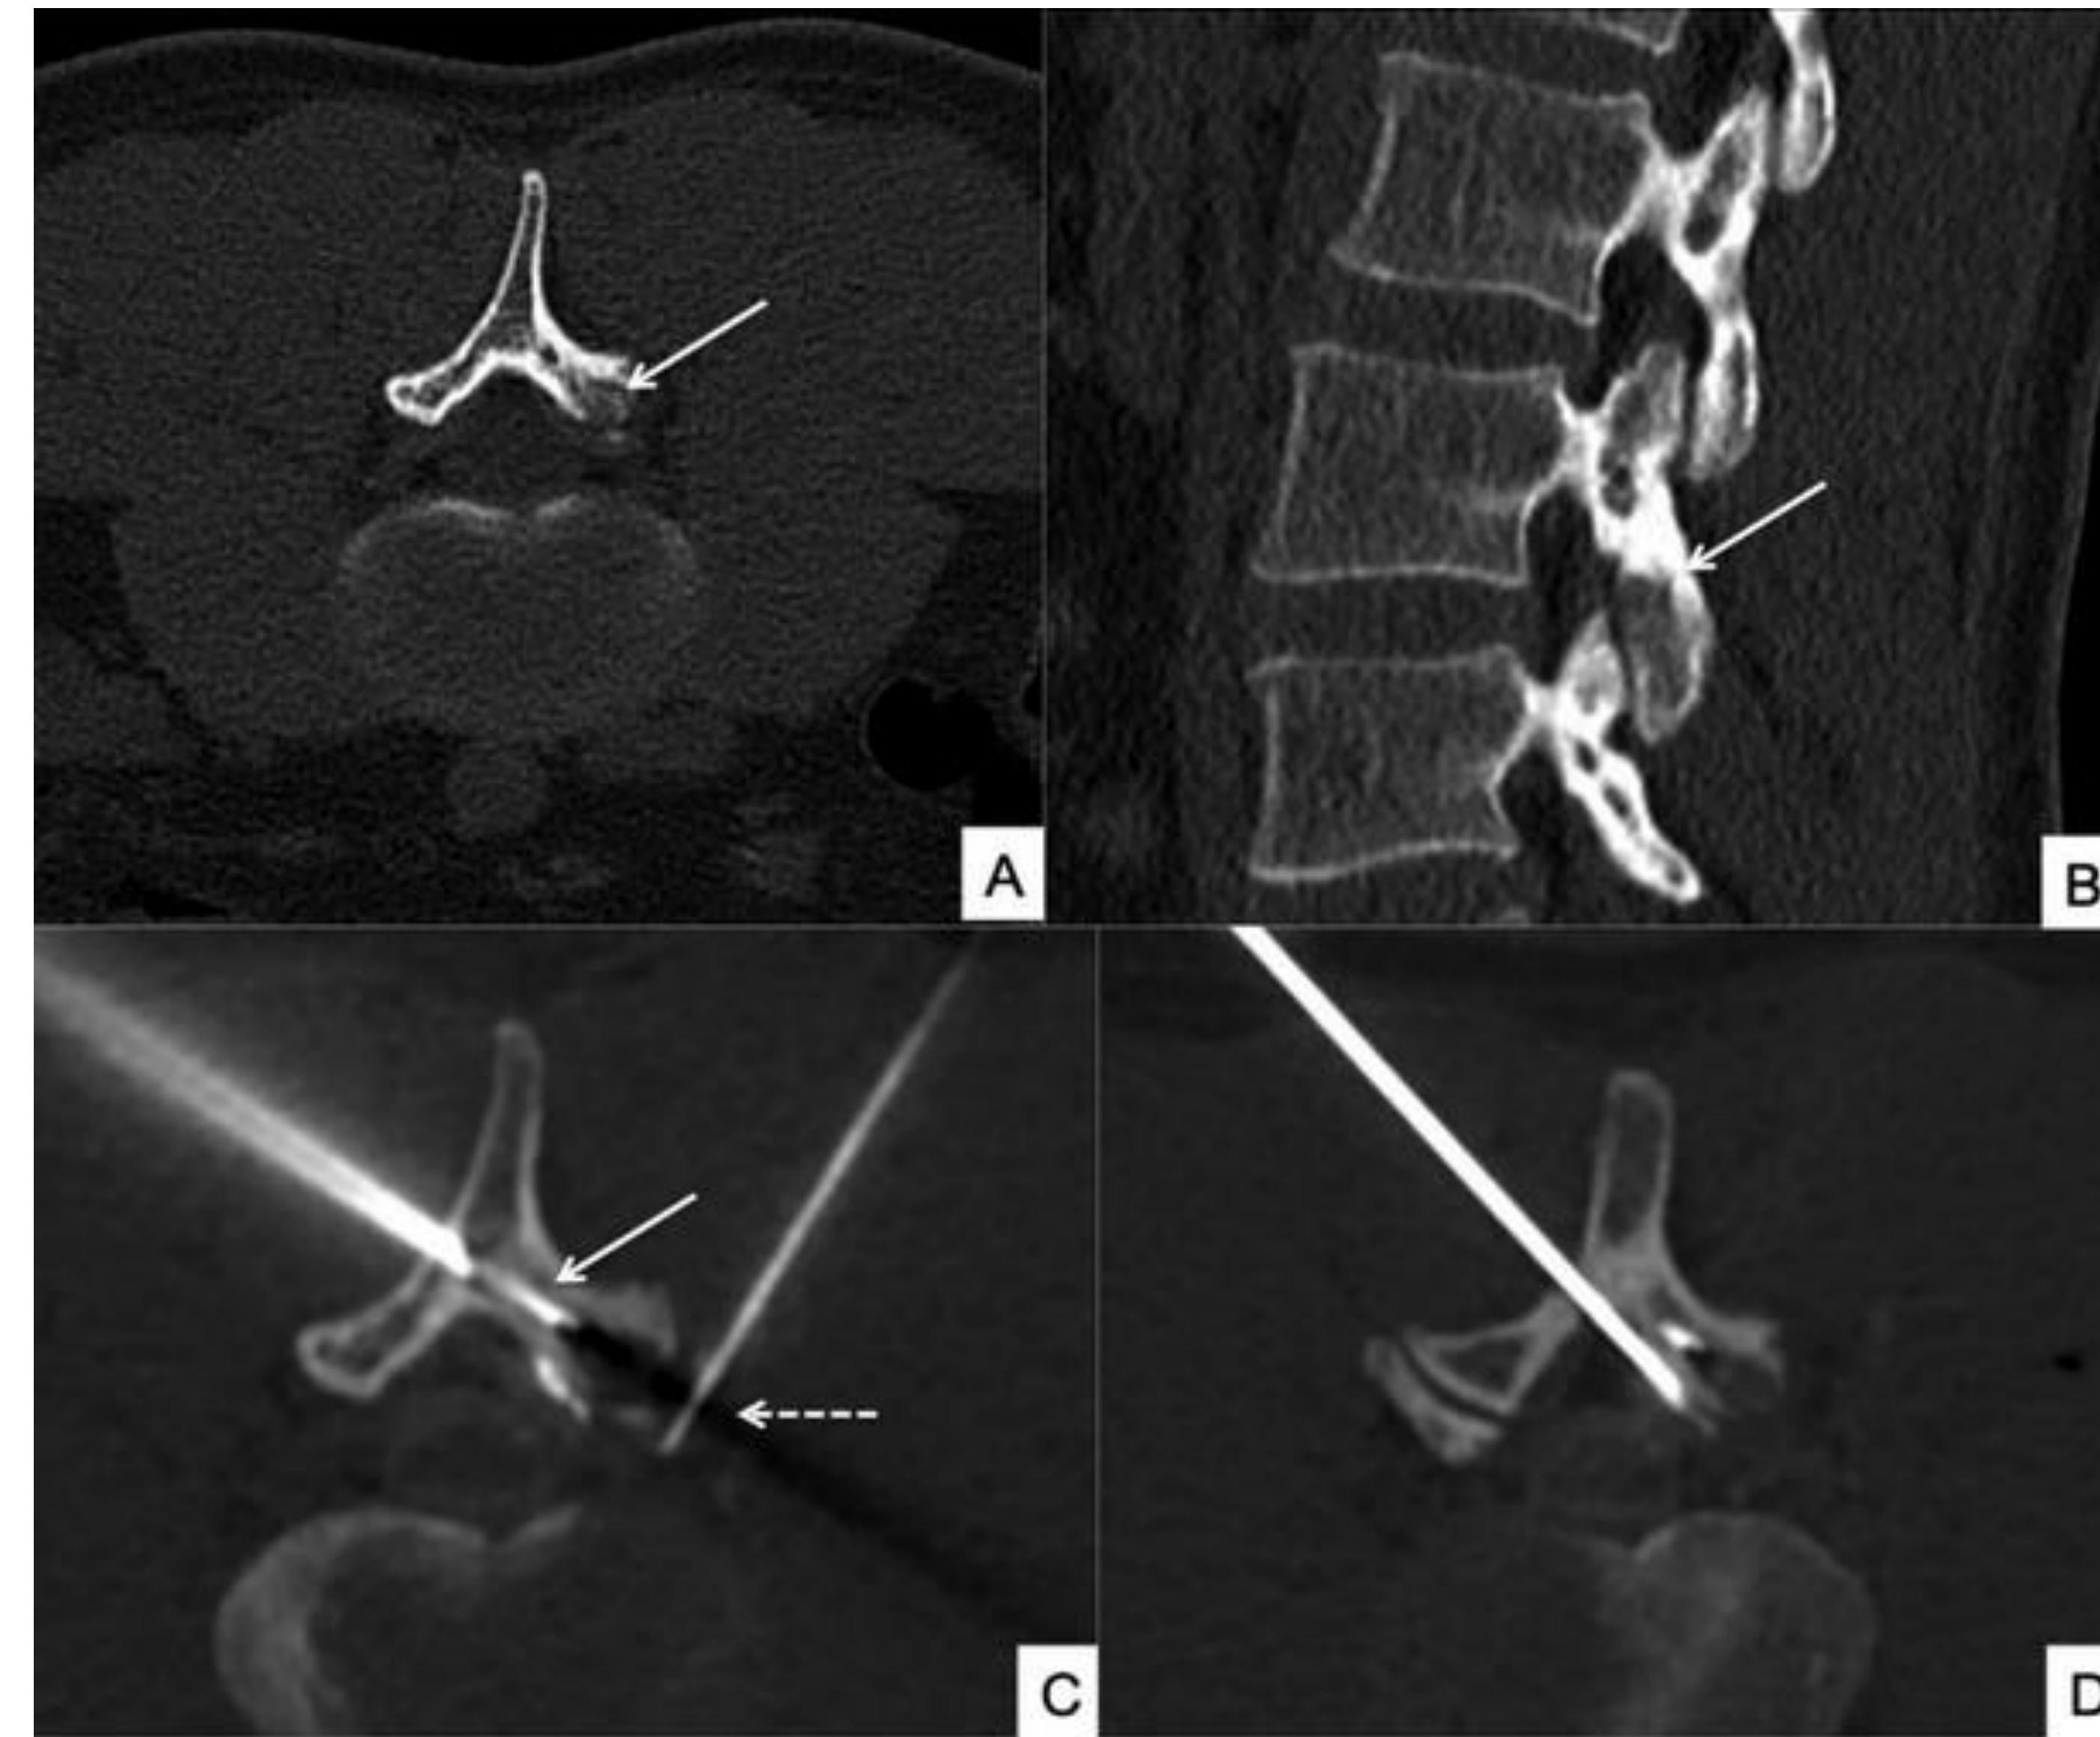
Axial (A) and sagittal (B) CT images demonstrating a patient with an osteoid osteoma (arrows indicate nidus) treated using laser ablation under a trans-osseous approach (C,D) Originally by Cazzato et al. [1]
